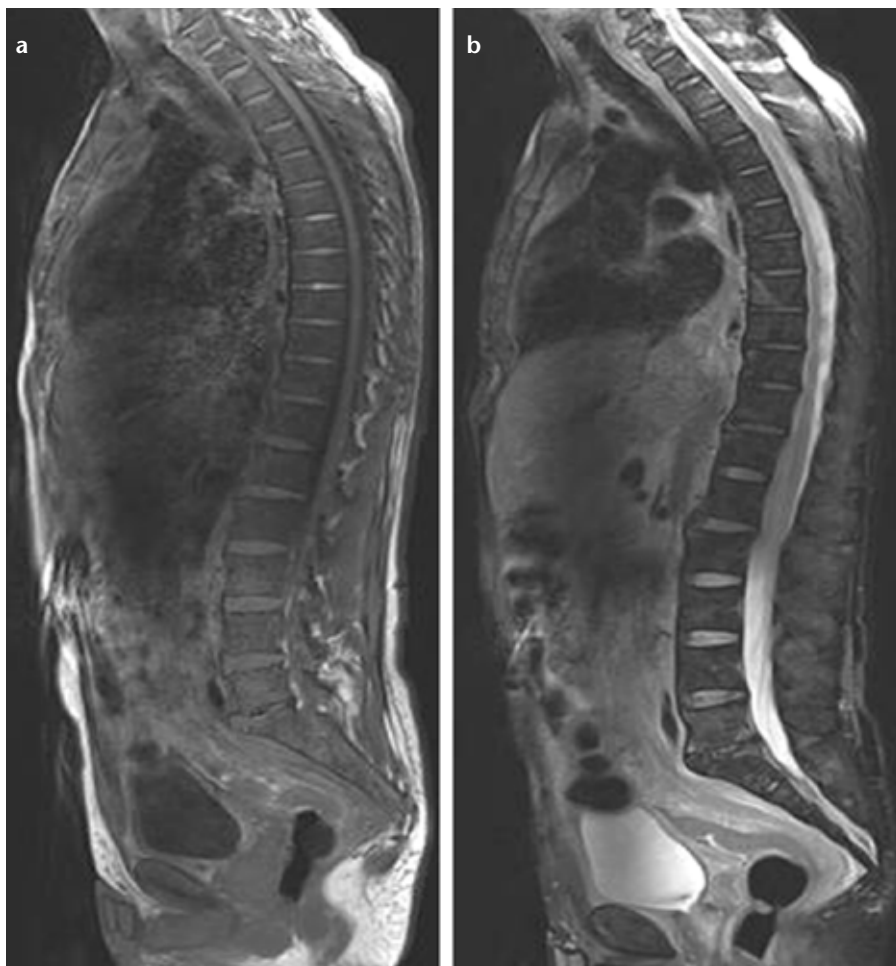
a, b. A 55-year-old male with Waldenström macroglobulinemia secondary to amyloidosis. The sagittal T1-weighted image (a) shows that bone marrow in the vertebral bodies and the sacrum is diffusely hypointense. The sagittal T2-weighted fat-saturated image (b) shows slight hyperintensity. Also note the extensive accumulation of amyloid in the peritoneum and retroperitoneum.
